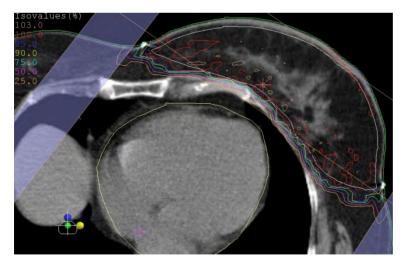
Left breast of a breast cancer patient treated entirely by protons delivered from a single field. The particle beam does not irradiate any part of the myocardium and the left anterior descending coronary artery is spared in this case, in contrast to the situation shown in Figure 3.2 where X-rays were used. Dose distribution is indicated by coloured isodose contours – see top left of figure for scale. (From Jones et al, 2009)
